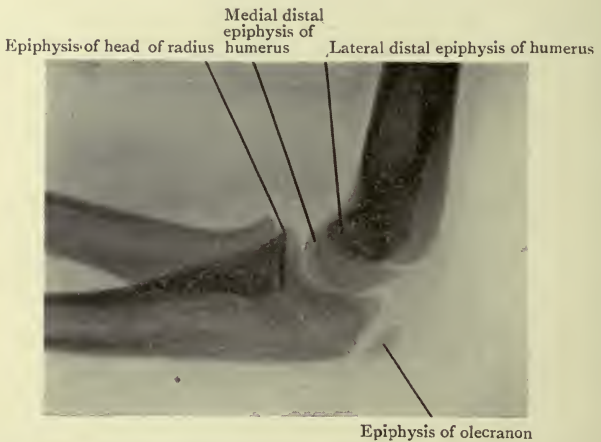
Lateral Radiograph of a half-bent young Elbow Joint.
